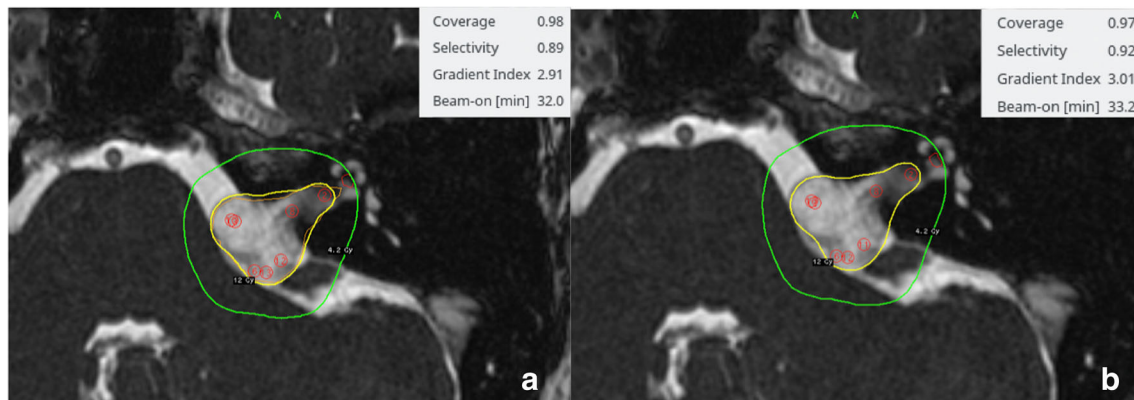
Screenshots during treatment planning of a left vestibular schwannoma Koos grade III, with serviceable hearing. a manual skull contouring and b CT scan contouring. The treatment indexes slightly vary, but the dose to the cochlea does not change
